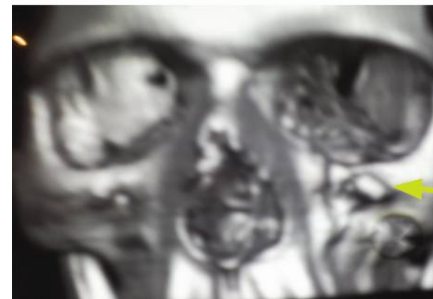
Photograph showing reconstructed 3D from CT of the same case.
